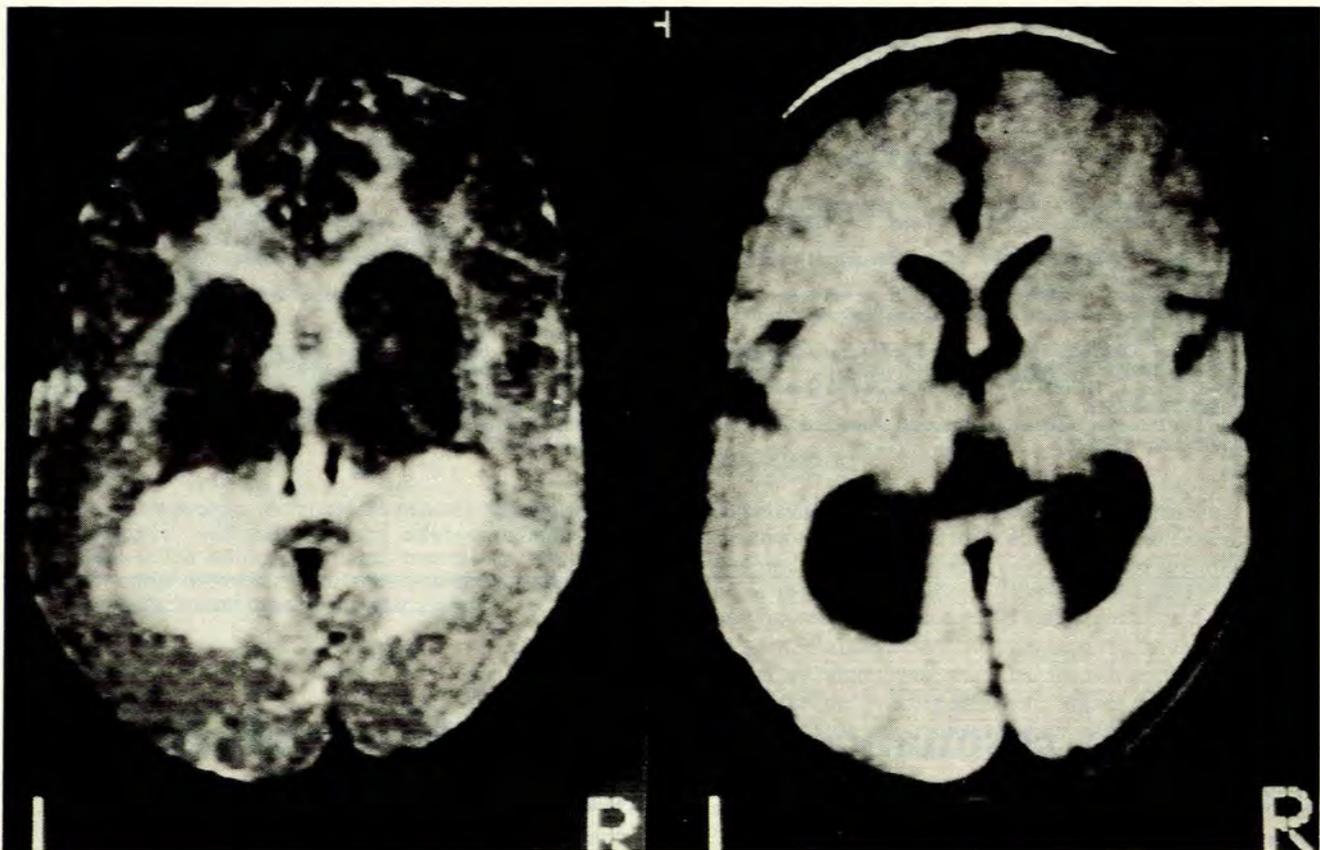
T2 MR images. Left: late echo (TE 27); and right: early echo (TE 120). These demonstrate increased thickness of grey matter with coarse gyri frontally and smooth occipital and temporal lobes. The sylvian fissures and posterior cortex are widened.
